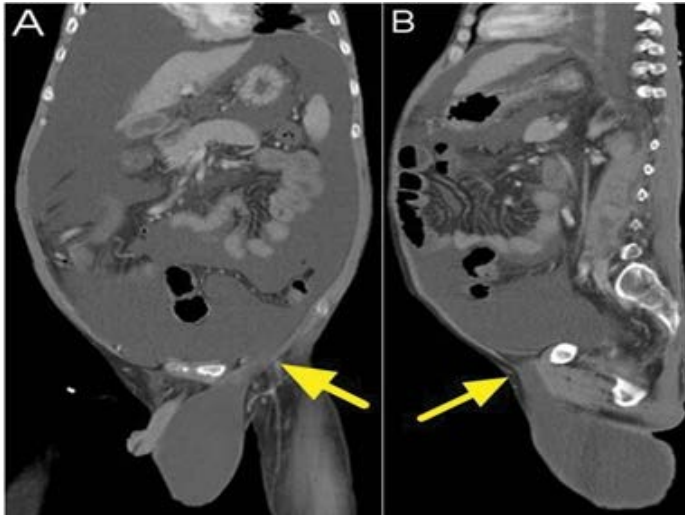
Computed tomography reveal massive ascites communicating between peritoneal cavity and the left scrotum through the internal inguinal ring (A, coronary view; B, sagittal view, yellow arrows).
